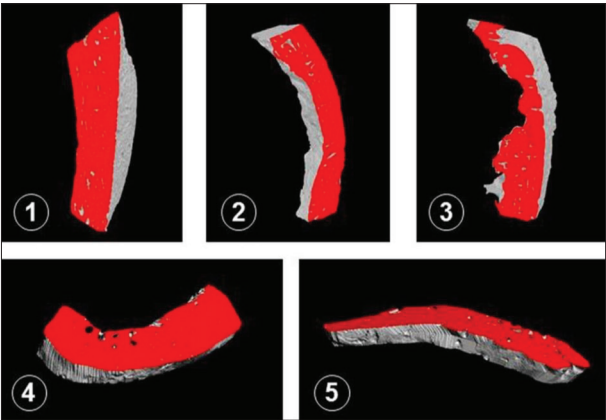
Micro-computed tomography scans 3D reconstruction: 1. supraorbital margin – orbit; 2. glabella; 3. mastoid process; 4. body of the zygoma; 5. pyriform aperture – perinasal
